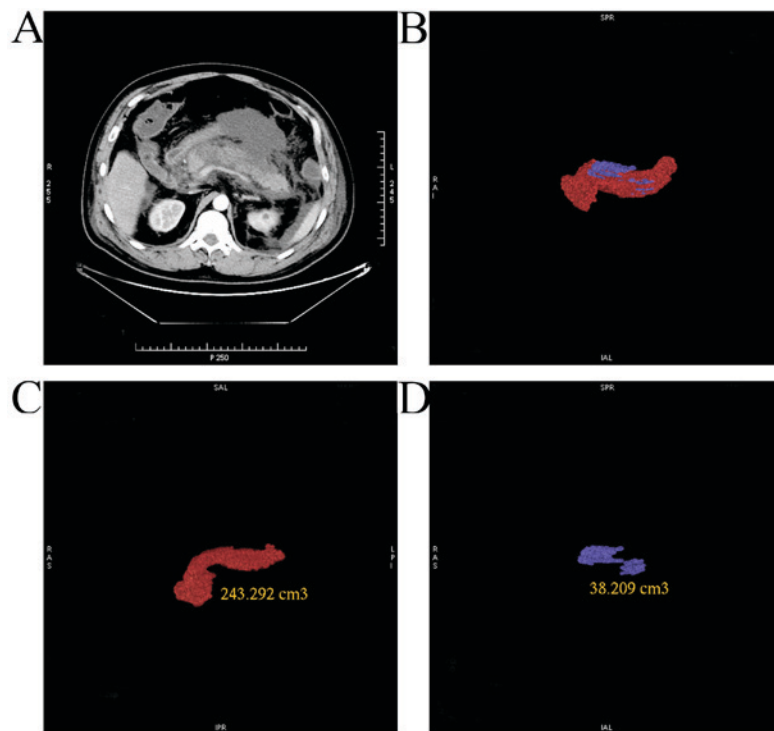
Peripancreatic fluid collection and extent of peripancreatic necrosis were obtained from computed tomography scanning with GE ADW4.5 workstation. (A) Axial imaging of arterial phase. (B) The entire pancreas is presented. (C) non-necrotic tissues of the pancreas were colored red, (D) necrotic tissues of pancreas were colored blue.
